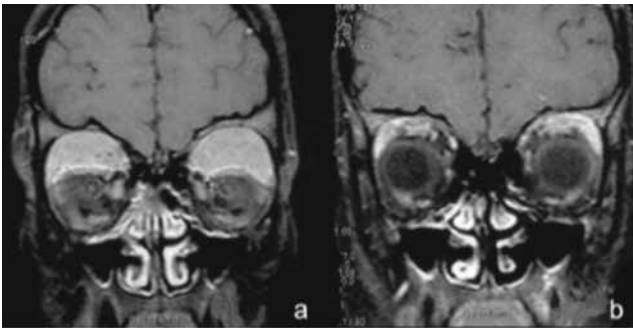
Orbital magnetic resonance images of patient with orbital granulocytic sarcoma before (a) and after (b) treatment
